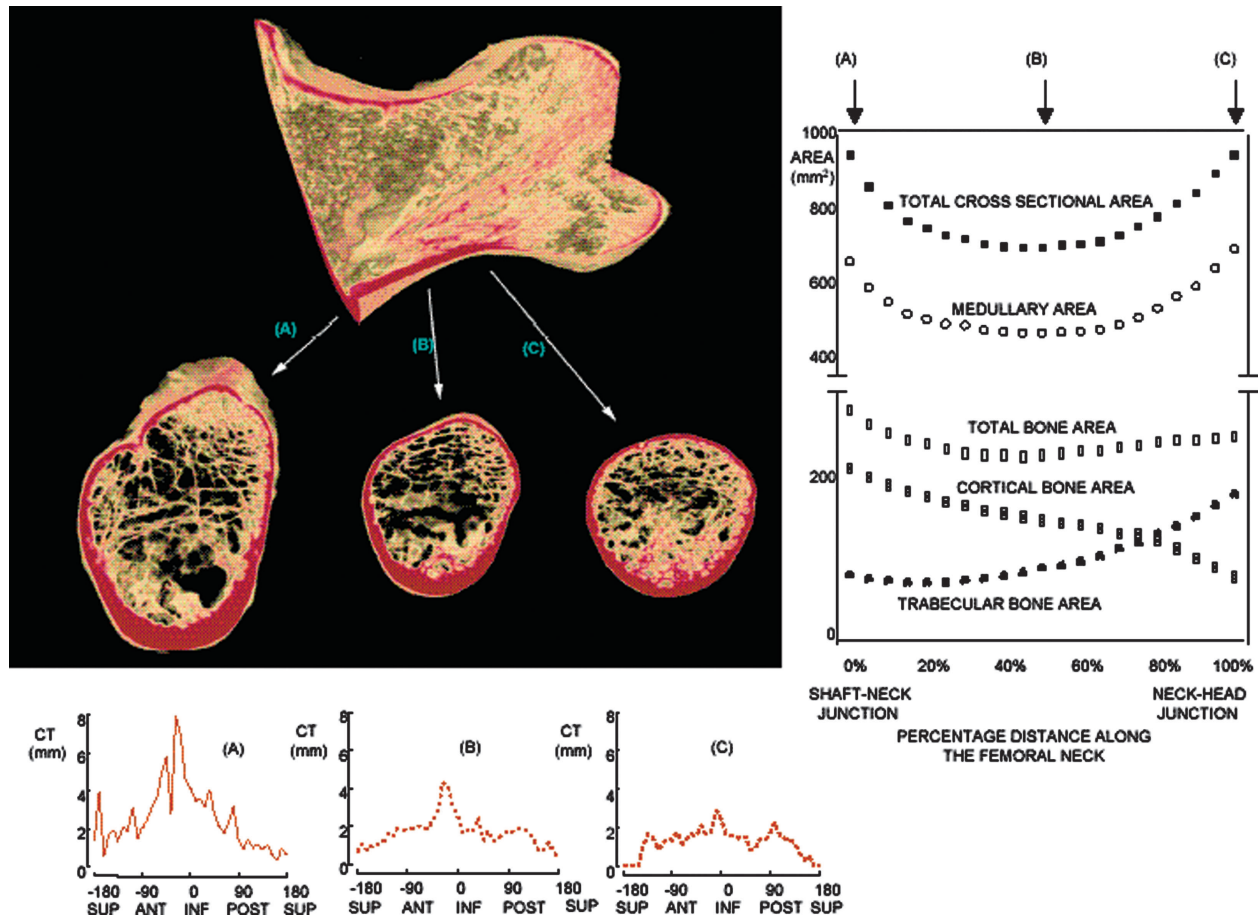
A left FN section measured using μ CT scanning is shown with three cross-sections along the FN (A) neck-shaft junction, (B) midfemoral neck, and (C) neck-head junction. Variability in the cross sectional shape is apparent with ellipticity and a thicker cortex inferiorly in A, with increasing circularity and a greater proportion of trabecular than cortical bone near the femoral head. The right panel shows the changes in total cross-sectional area, medullary and total cortical and trabecular bone areas from the neck-shaft junction to the neck-head junction. Total bone area remained similar along the FN, although size, shape, cortical, and trabecular bone areas differ. CT, cortical thickness; sup, ant, inf, post, superior, anterior, inferior, and posterior, respectively.
